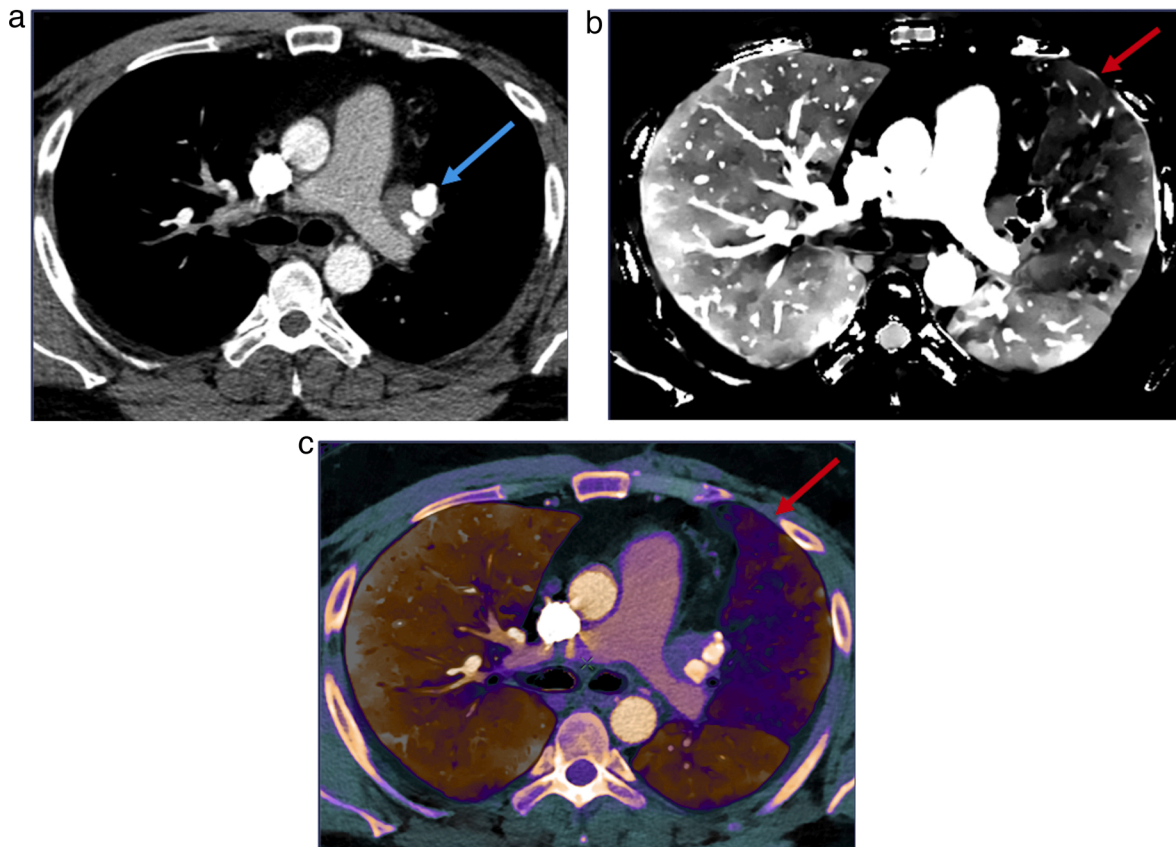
Better diagnostic certainty with DECT. A 38-year-old male with history of annual episodes of massive hemoptysis, which has been going on for several years and resolved each time with antibiotics and steroids and cough suppression. Initial axial conventional CT image (a) demonstrate a partially calcified mass within left aspect of the mediastinum (Arrow) at the expected location of left superior pulmonary vein (vein not visualized). The iodine density (b) and overlay images (c) demonstrate a large perfusion defect of the left upper lobe lung (Arrows), in the distribution of left superior pulmonary vein. Given the patent pulmonary arteries and above-mentioned findings, diagnosis of pulmonary venous occlusion secondary to granulomatous disease was considered.
